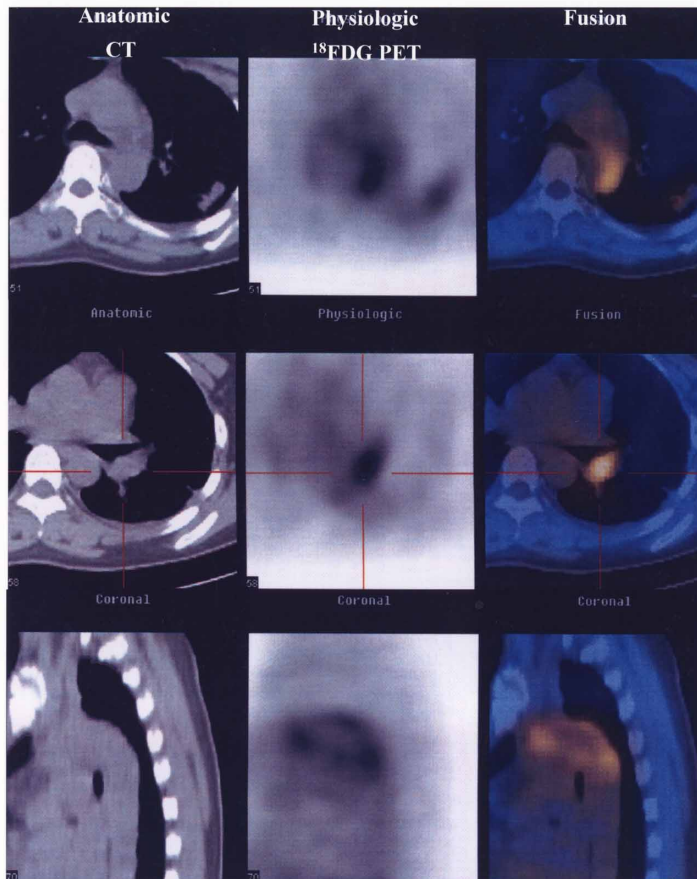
Computed tomography (left), fluorine-18-fluorodeoxyglucose positron emission tomography (center), and fusion images (right) before steroid treatment. High uptake of ^{18}F FDG PET was observed in the proximal portion of the left pulmonary artery and in the wall of the thoracic aorta that showed wall thickening on CT.
